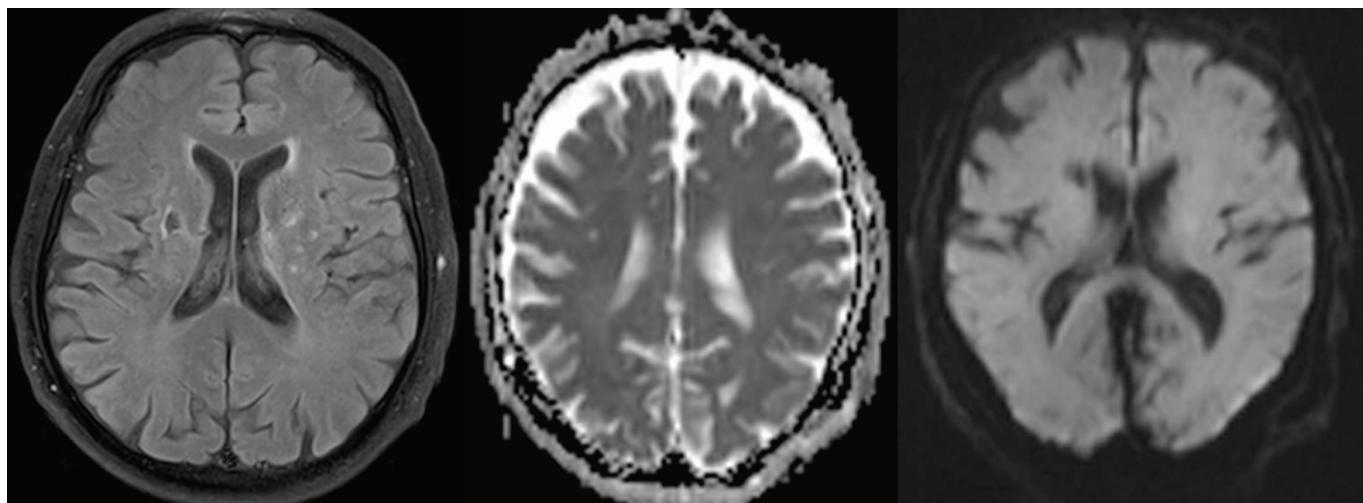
Diffusion-weighted and fluid-attenuated inversion recovery magnetic resonance imaging of a 75-year-old man. Preoperative scans depicted old ischemic lesions bilaterally in white matter. No diffusion abnormalities were seen on the postoperative scan.
